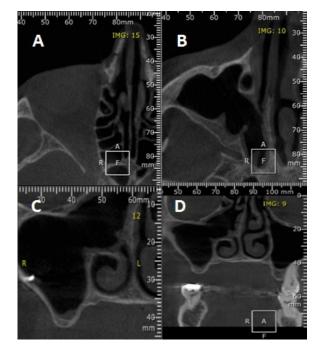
Evaluation by Cone Beam, June 2017. Axial cut (A and B) and coronal cut (C and D).
